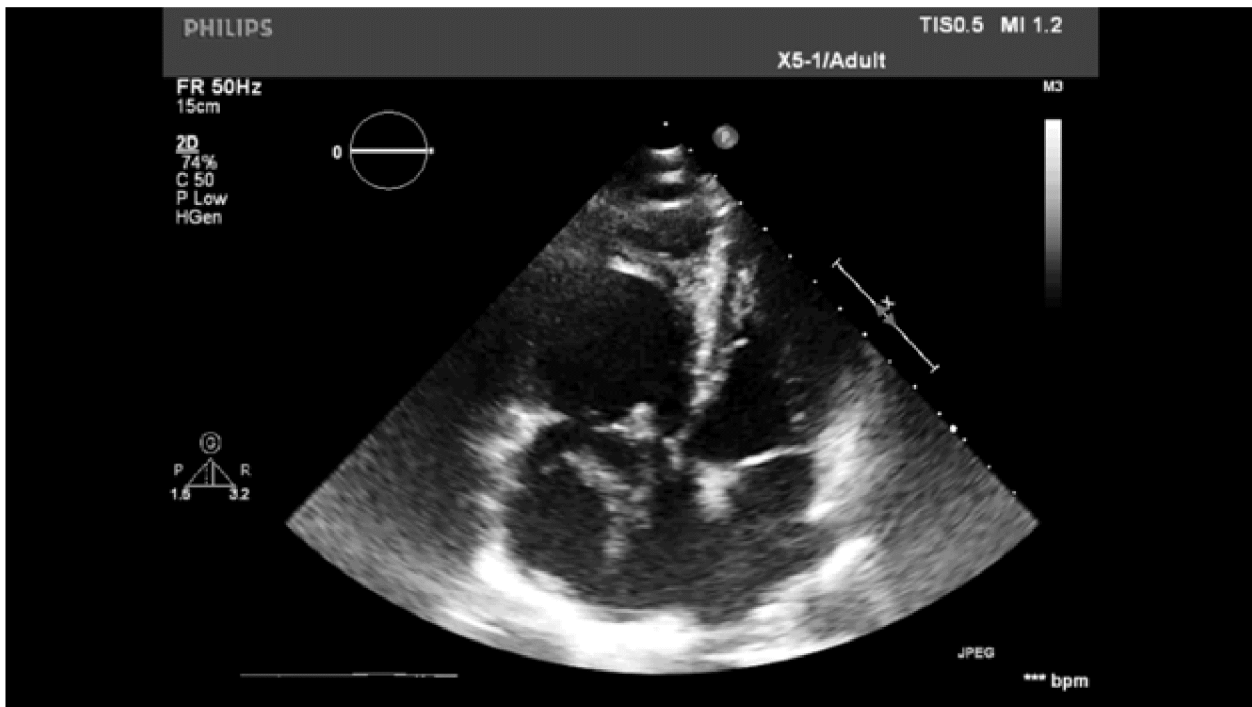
2D echo apical 4C view showing enlarged right atrium and ventricle with large serpiginous thrombus in right atrium transiting to left atrium and right ventricle.
